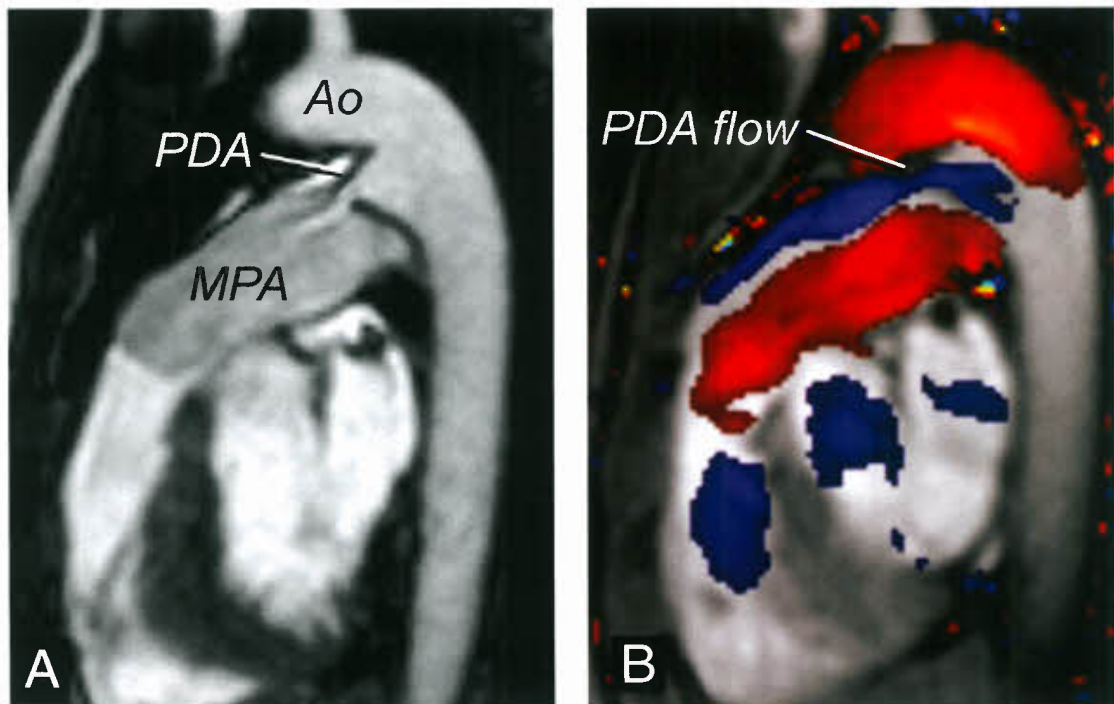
MRI evaluation of PDA. A: Cine SSFP in an oblique sagittal plane showing small PDA; B: Color-coded cine phase velocity MRI showing flow from the aortic isthmus (Ao) to the main pulmonary artery (MPA).
